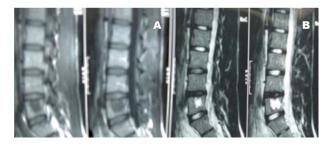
Case 2, Sagittal T2-weighted and T1-weighted MR images of lumbar vertebrae show the body and homogeneous cystic lesion of L5.
